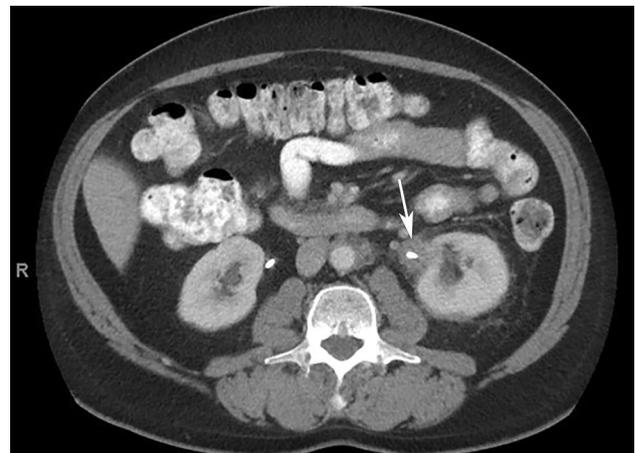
Circumferential ureteral wall thickening due to retroperitoneal fibrosis. An axial portal venous phase contrast-enhanced CT through the abdomen in a patient with bilateral ureteral stents shows marked proximal left ureteral wall thickening (arrow). There is also a small ring of circumferential para-aortic soft tissue, characteristic of the diagnosis. The patient was subsequently treated with and responded to high-dose corticosteroids
